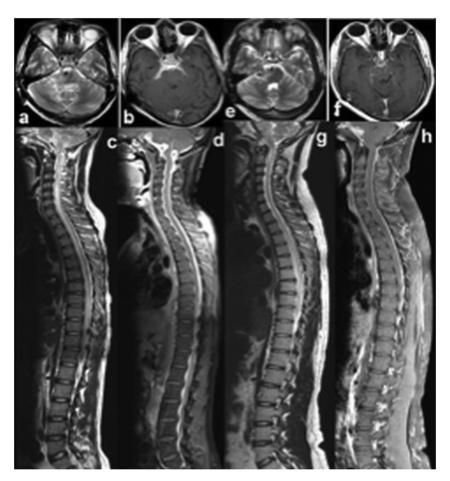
MRI brain axial T2 (a) shows T2 hyperintensity in the right cerebellopontine angle cistern, right middle cerebellar peduncle and dorsal pons. Post-gadolinium T1-WI (b) shows enhancement in the interpeduncular cistern and suprasellar cistern. Whole spine sagittal T2-WI (a) and post-gadolinium T1-WI (b) show holocord T2 -hyperintensity with thick leptomeningeal enhancement suggesting arachnoiditis with cord edema. Follow-up MRI brain axial T2 (e) image show decrease in signal change in right middle cerebellar peduncle and dorsal pons. Multiple T2 hypointense lesions are seen in right cerebellopontine angle cistern suggesting organized granulomas. Post-gadolinium T1-WI (f) show decrease in enhancement in interpeduncular and suprasellar cistern. Follow-up MRI of whole spine-sagittal T2-WI (g) and post-gadolinium T1-WI (h) shows decrease cord T2-hyperintensity (g) and leptomeningeal enhancement (h).
